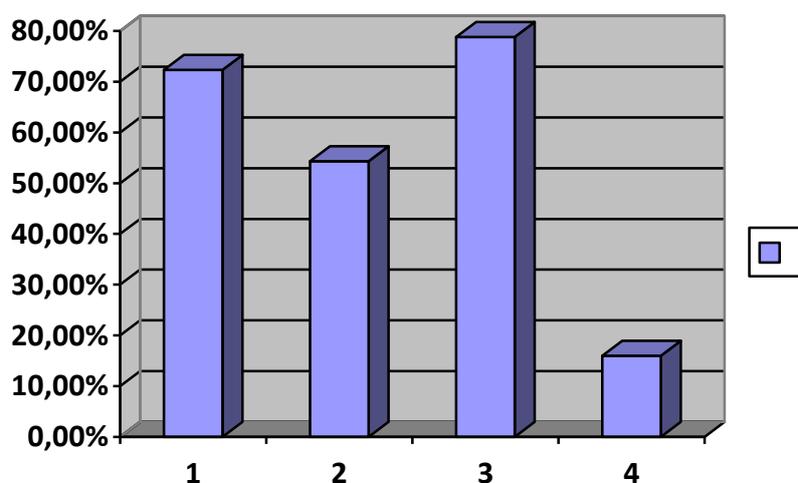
Distribution of the reasons for prescribing CBCT. 1. implant cases; 2. evaluation of impacted teeth; 3. endodontic purpose; 4. orthodontic assessment.
